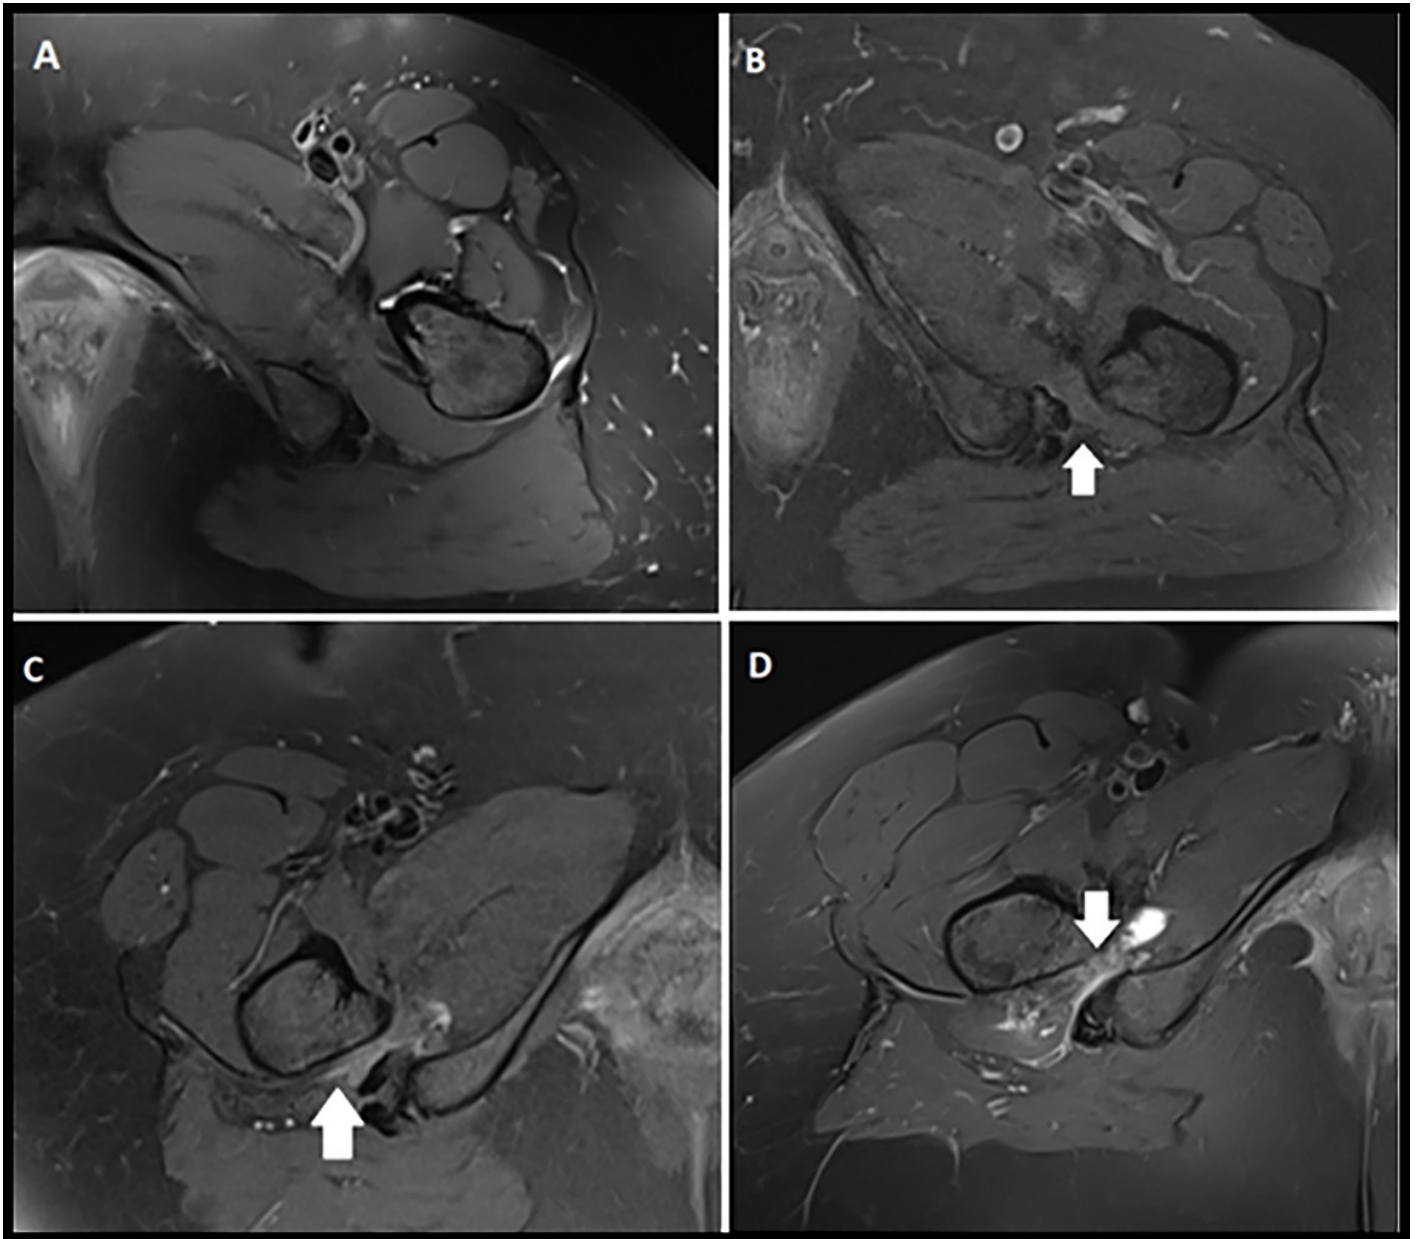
Grading of edema in the quadratus femoris muscle (QFM) on axial T2 MRI: A Grade 0 (no edema), B Grade 1 (mild edema), C Grade 2 (moderate edema), D Grade 3 (severe edema). White arrows indicate the location of the edema
